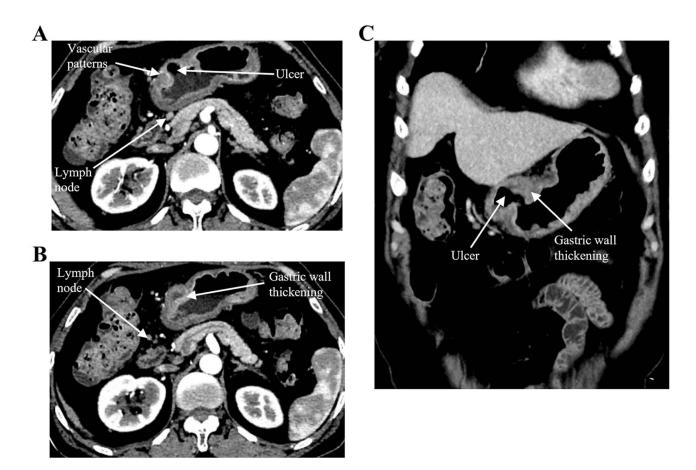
Figure I (A) Vascular patterns can be found within the thickened mucosa. Ulcerative lesions present on the lesser curvature and anterior wall of the stomach, with multiple visible lymph node shadows in the vicinity. (B) The abdominal enhanced CT scan indicates a conspicuous thickening of the gastric wall in the gastric antrum region, measuring approximately 12.5 mm at its thickest point. (C) Coronal reconstruction of CT images.
